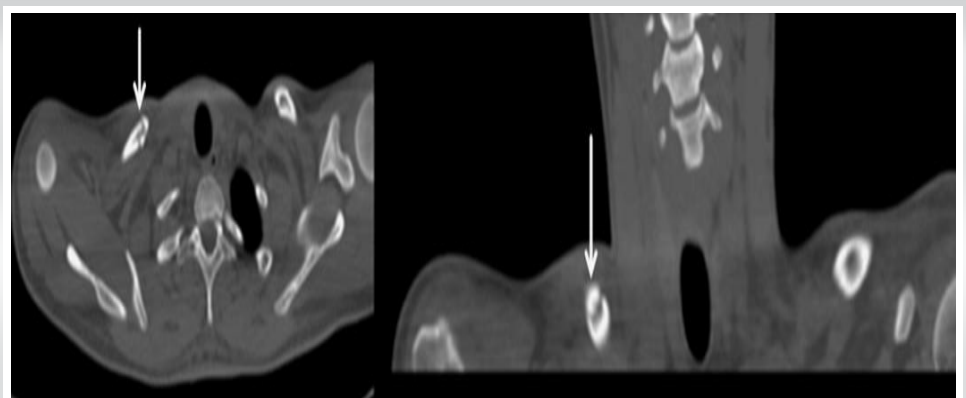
Axial and coronal computed tomography scan demonstrating a non-displaced fracture of the midshaft of the right clavicle.
